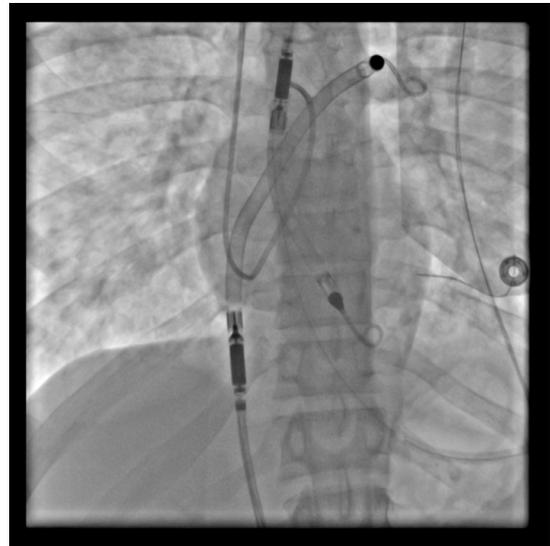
Chest X-ray shows left ventricular impella 5.0 through left axially axis, impella RP through right femoral artery access and Swan Ganz catheter through right internal jugular access.
